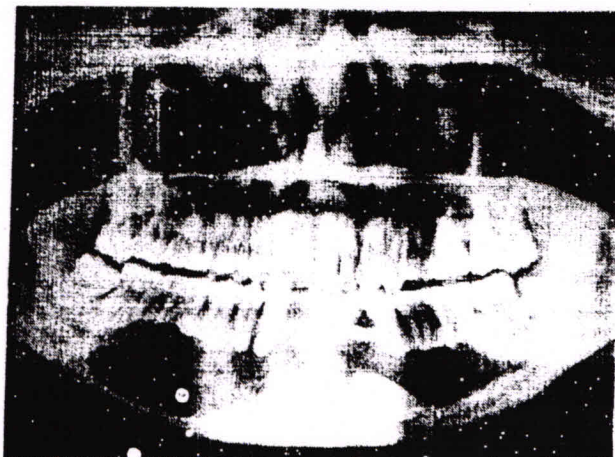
Orthopantomograph view showed well-defined unilocular radiolucency with impacted 33
